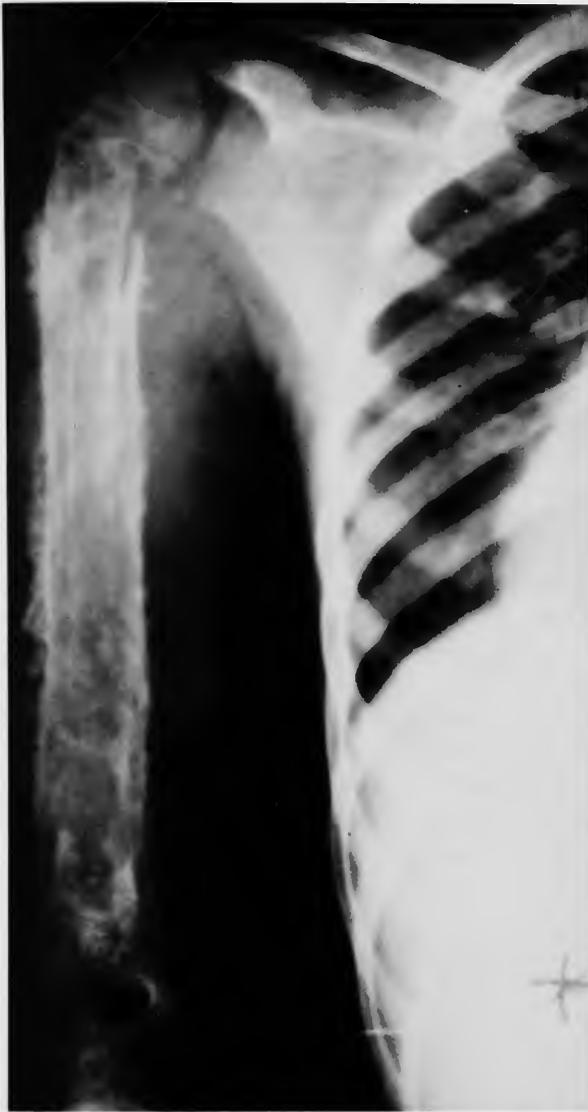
X-ray of right humerus, of sickle-cell anemia with *Salmonella* osteomyelitis. (Nigerian negro, courtesy Dr. Stanley Bohrer, Ibadan, Nigeria.)
